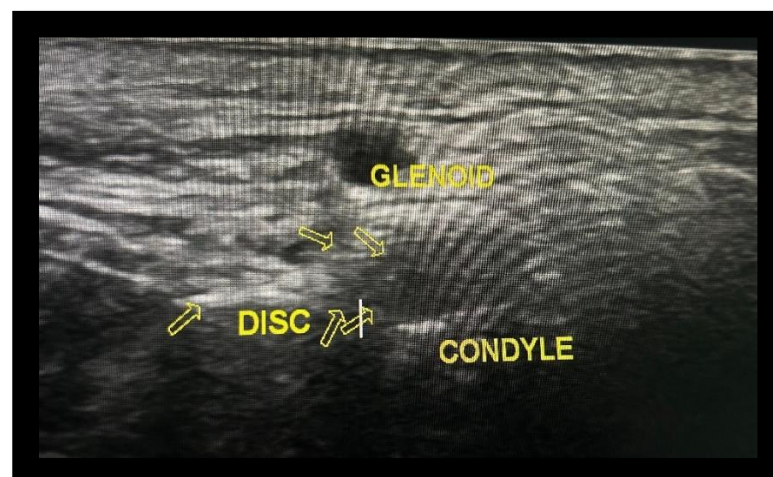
Ultrasonography showing disc with pathology showing anterior disc displacement
